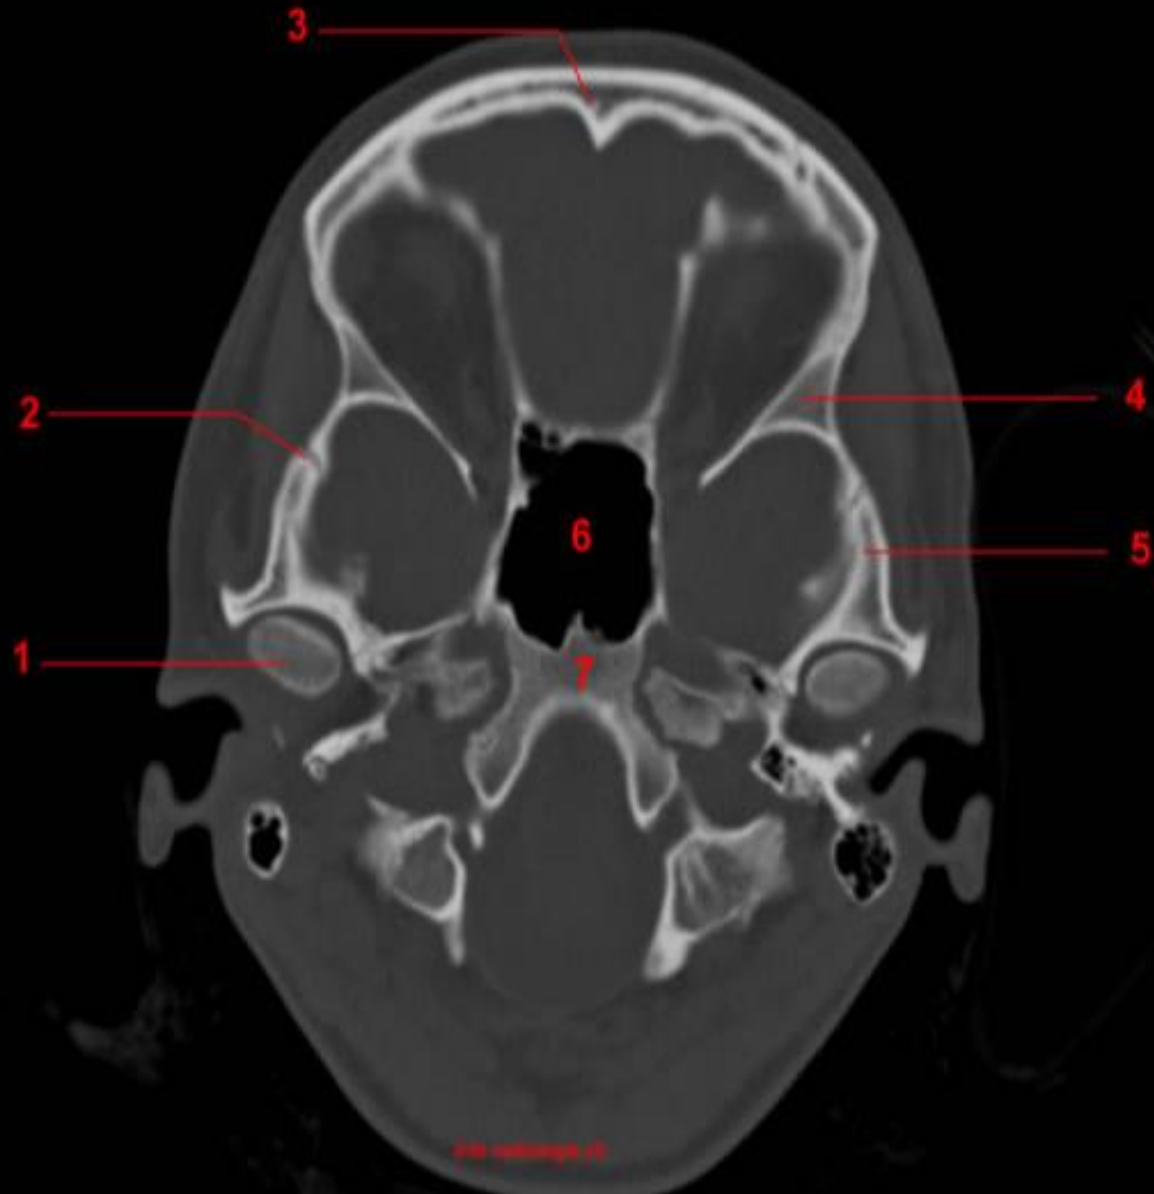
CT Anatomy of skull, axial reconstruction, bone window.
